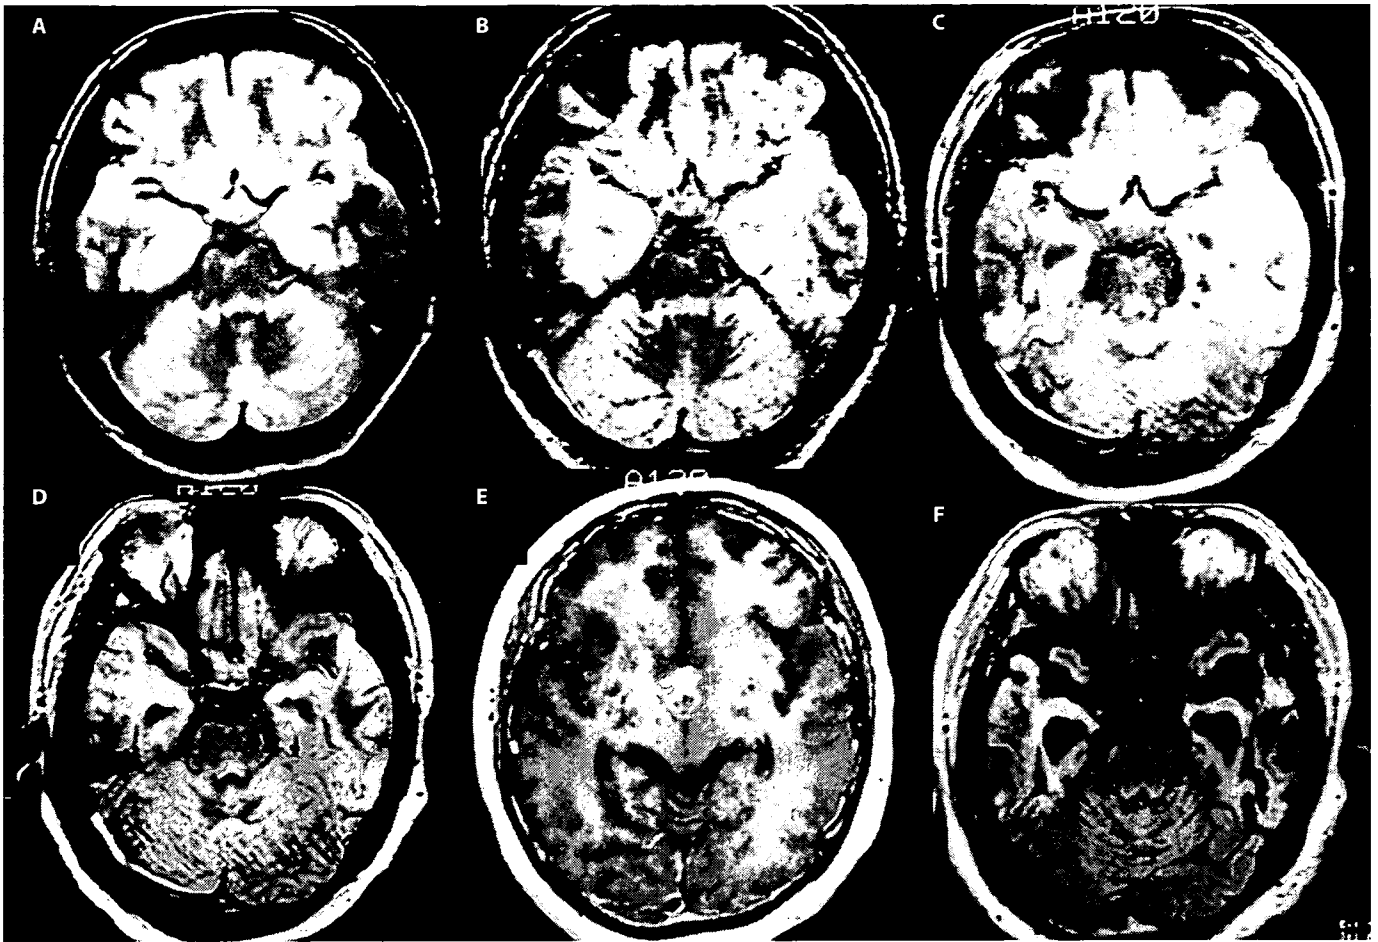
Serial axial FLAIR MRI (A–D, F) and gadolinium-enhanced T₁-weighted image (E). Hyperintense lesions were seen in the bilateral hippocampus in August 1995 (A) and November 1995 (B). Expansion of the hyperintensity was seen in the left temporal lobe in January 1998 (C). In February 1999, hyperintensity was detected in the right temporal lobe and gadolinium enhancement in the hypothalamus (D, E). Severe atrophy of the bilateral hippocampus was observed in March 2001 (F).
